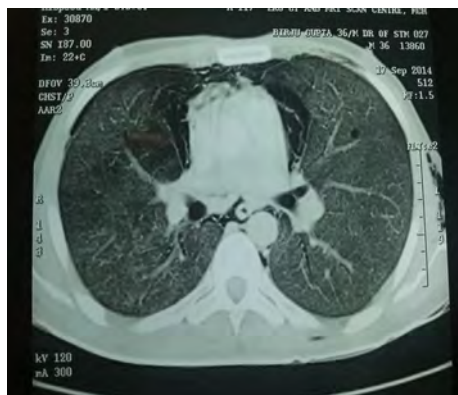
CT scan showing pneumomediastinum on both sides
